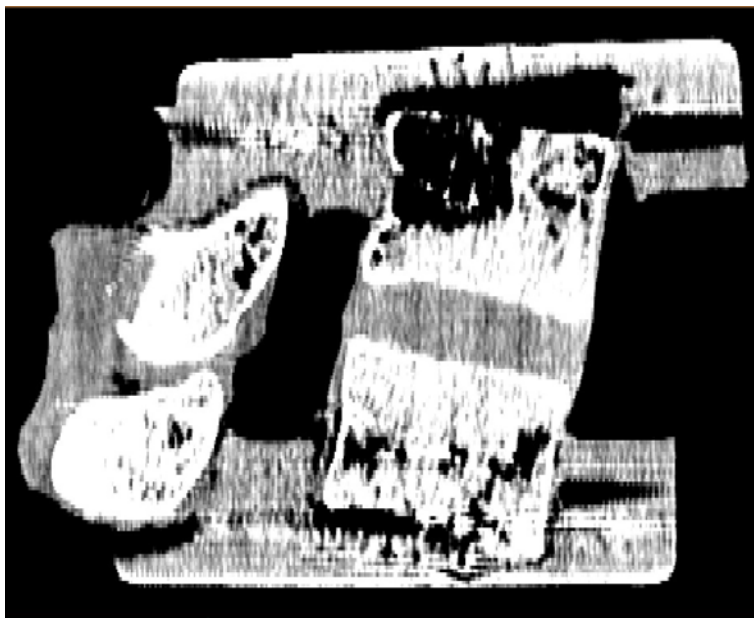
CT scan showing fixation pull-out (FSU 3032 L4-L5).
